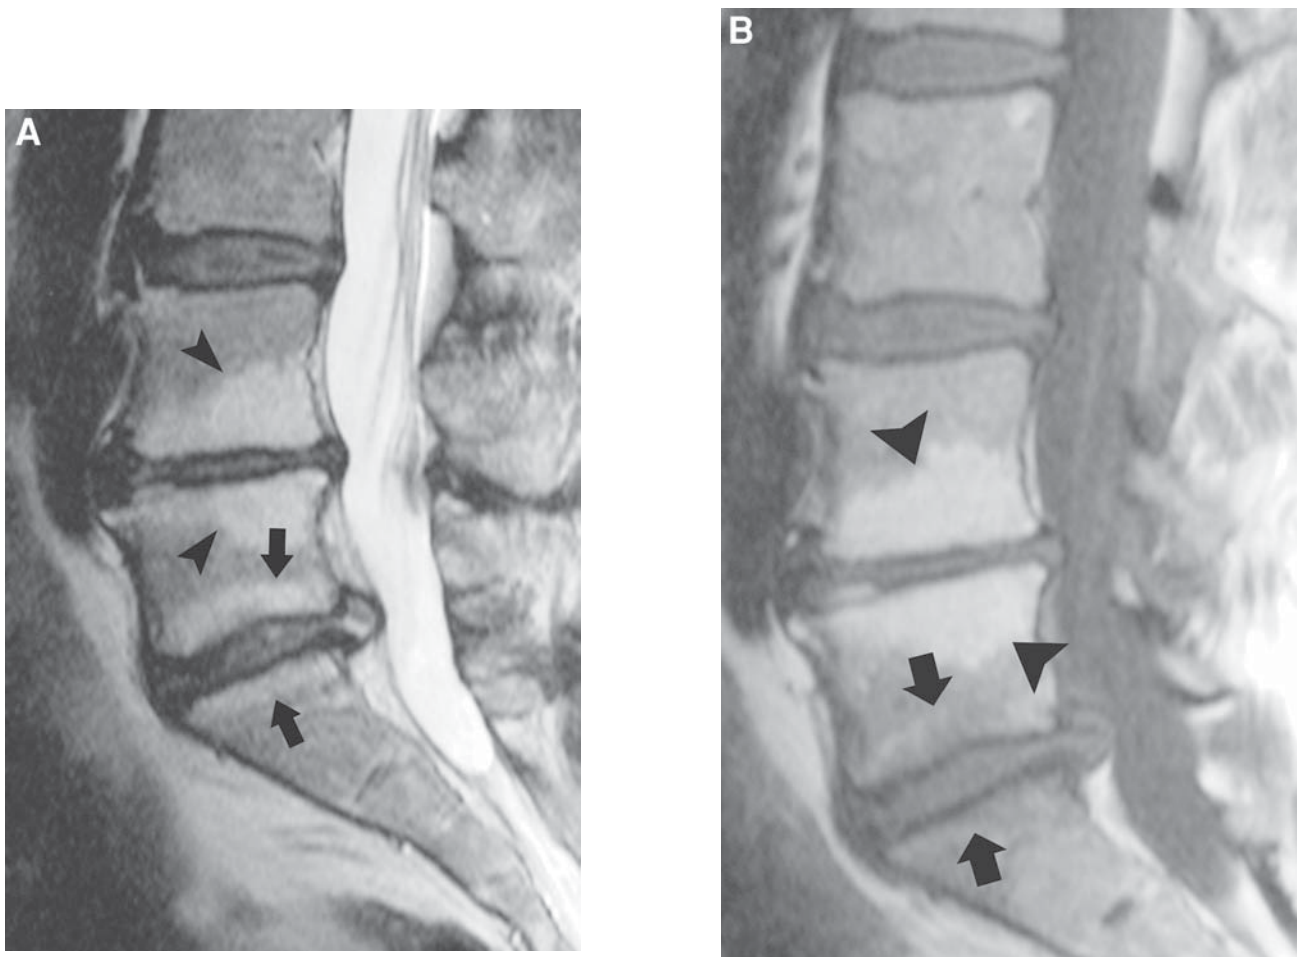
Reactive marrow changes. Sagittal T2-weighted image (A) and sagittal T1-weighted image (B) demonstrate type I reactive marrow changes at the L5–S1 level with areas of increased T2 (*arrows*) and decreased T1 signal (*arrows*). Type II changes are present at the L4–5 level with increased T1 and T2 signal (*arrowheads*).
